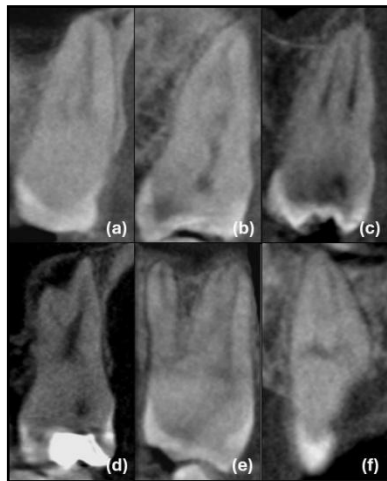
Coronal CBCT images of the mesiobuccal roots of maxillary molars demonstrating different canal configurations, a) Vertucci Type II, b) Vertucci Type III, c) Vertucci Type IV, d) Vertucci Type V, e) Vertucci Type VI, f) Vertucci Type VII.
